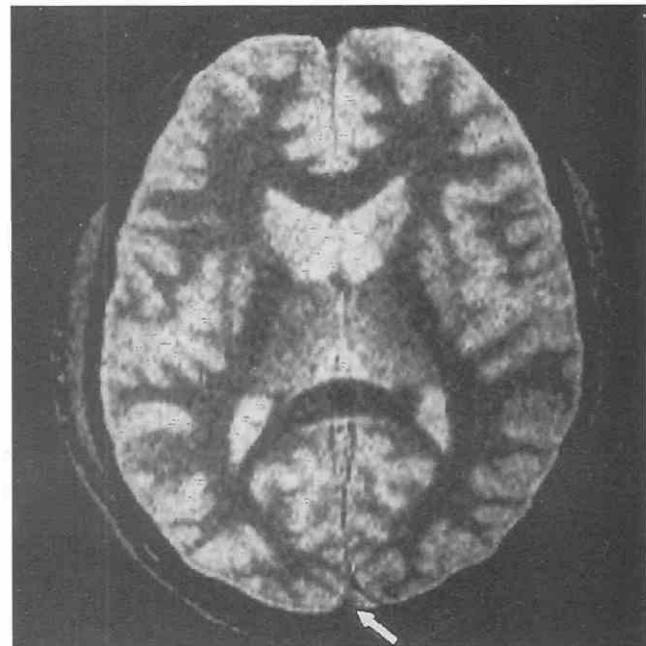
T1-weighted image of the head for (A) 15 degrees and (B) 30 degrees. Since the T1 of blood is longer than that of gray matter, it appears darker if it is saturated but may appear isointense if some inflow effect remains. Imaging parameters: TR = 40 msec, TE = 8 msec; 64 partitions, 2-mm slice thickness; matrix size, 256 × 256.
